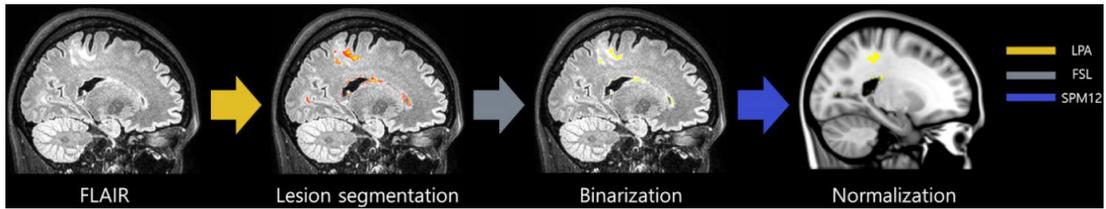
Image preprocessing. We segmented lesions from FLAIR images to act as a lesion probability map, binarized them with a 50% threshold, and normalized them to the standard Montreal Neurological Institute space.
